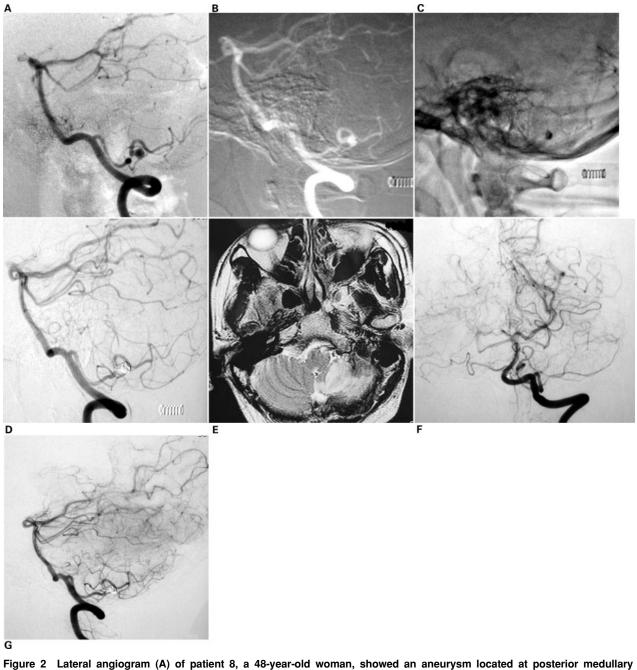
Lateral angiogram (A) of patient 8, a 48-year-old woman, showed an aneurysm located at posterior medullary segment of the left PICA. By injection of Onyx-18, the aneurysm was occluded (B, C). Post-procedural (E) angiogram revealed that the aneurysm was completely occluded and the parent vessel was patent. MRI scan (E) showed cerebellar infarct with compression of the fourth ventricle. Follow-up angiography (F, G) showed complete occlusion of the aneurysm with parent artery preservation.
